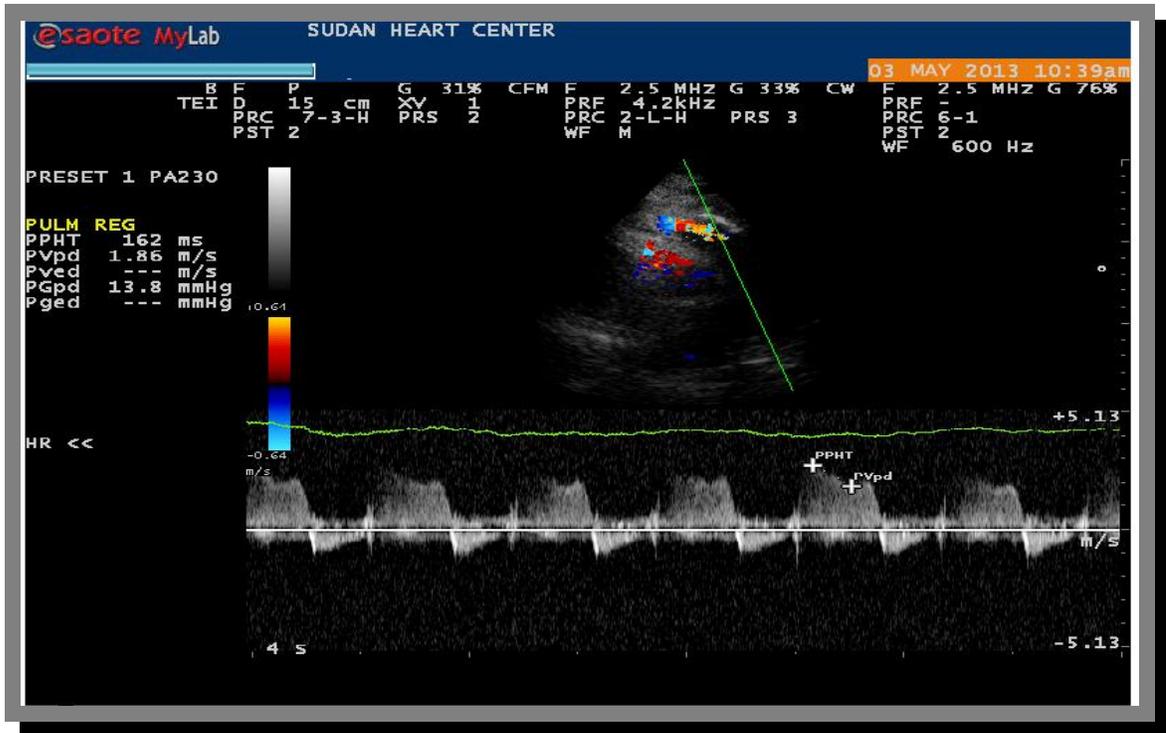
Continuous wave Doppler signal of pulmonary regurgitation with a peak velocity of approximately 1.86 m/s.
